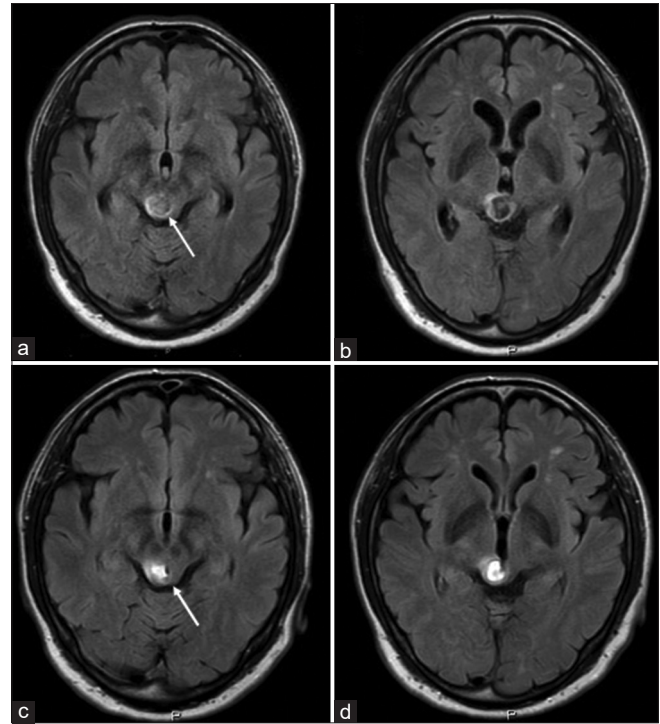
Time course of magnetic resonance imaging ([a and b] on admission [c and d] after 11 days). (a and c) are slice of the level of pineal gland, and (b and d) are slice of the upper level of pineal gland. The hematoma remained in the right cover and the edematous change of the posterior commissure disappeared (arrow).
